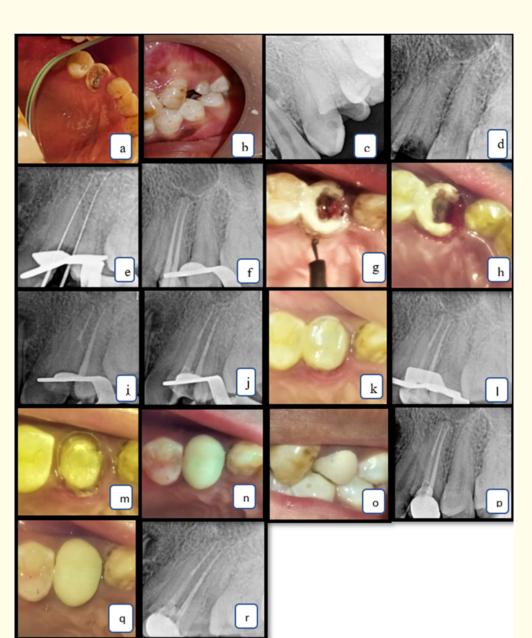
(a) and (b) pre-operative image (c) and (d) pre-op radiograph (e) working length radiograph irt 24 (f) image showing crown lengthening with electrosurgery irt 24 (g) immediately after crown lengthening (h) radiograph showing obturation irt 24 (i) radiograph showing post preparation (j) radiograph after post cementation (k) image after core build up irt 24 (l) radiograph after core build up irt 24 (m) image after tooth preparation irt 24 (n) annd (o) image after crown cementation irt 24 (p) radiograph after crown cementation irt 24 (q) radiograph after 1 month follow up irt 24 (r) image after 1 month follow up irt 24.
